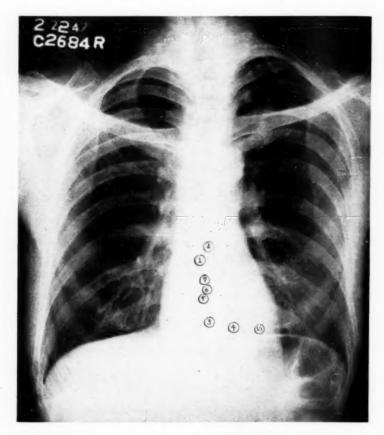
X-ray film of a patient with a normal heart showing various locations of an intracardiac electrode as projected on the thoracic surface by the central ray of the fluoroscope. At Points 1 and 2 it was in the right atrium; at Points 3 to 7 it was in the right ventricle. The location of Lead V_3 on the chest is shown for comparison.
